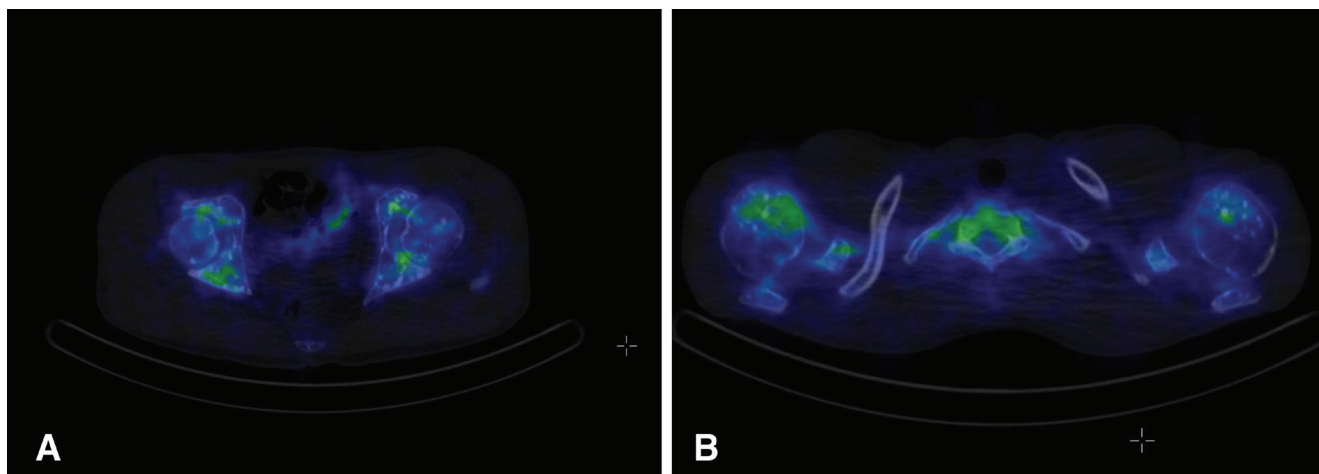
Multiple, sclerotic lesions were detected in thoracic bones, shoulders, and both femur and pelvic bones by CT but radiotracer uptake was observed in some sclerotic lesions on SPECT-CT images (A, B). Laboratory tests were within normal limits except a slightly elevated alkaline phosphatase value of 126 U/L (range: 30-120 U/L).
